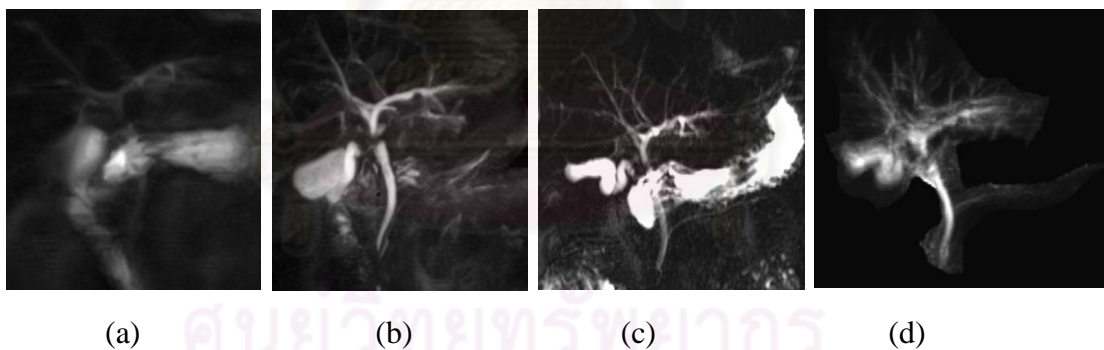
Case No. 10 The MRCP imaging 2D, 3D at MRI 0.4 T (a),(b) and 2D, 3D at 3.0 T (c),(d) respectively
